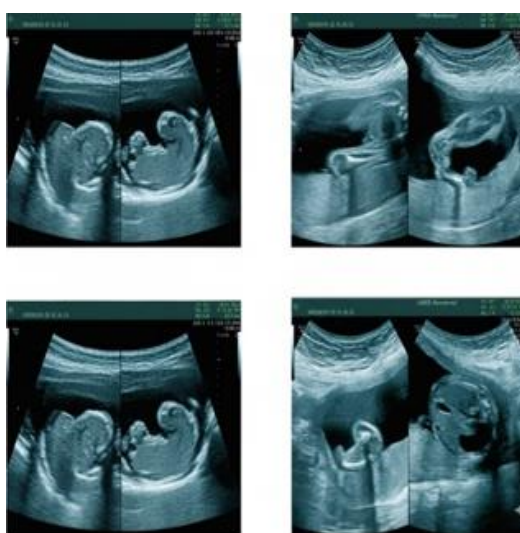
Ultrasound at 26-week of gestation showing normal cranial and thoracic structures with preserved anatomic outlines.
